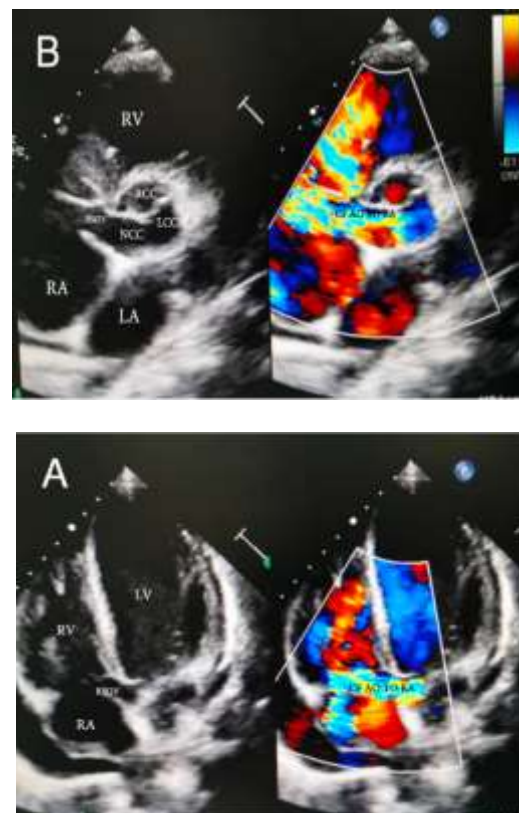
Transthoracic modified 5 chamber view (A) and AV short axis view (B) show colour flow (CF) from aorta (AO) to right atrium (RA) through the ruptured sinus of Valsalva aneurysm. (LV: left ventricle, RV: right ventricle, RA: right atrium, RSOV: ruptured sinus of Valsalva, RCC: right coronary cusp, LCC: left coronary cusp, NCC: noncoronary cusp, CF: colour flow, AO: aorta).
